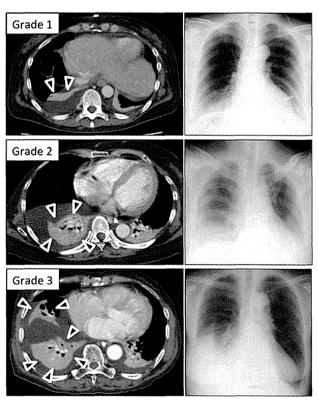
Chest CT and radiograph of each grade of postoperative atelectasis. Atelectasis is indicated by arrowheads. Grade 1 atelectasis is defined as involvement of ≤ 1 subsegment or discoid atelectasis; grades 2 and 3 indicate the involvement of 2 and ≥ 3 subsegments, respectively.
